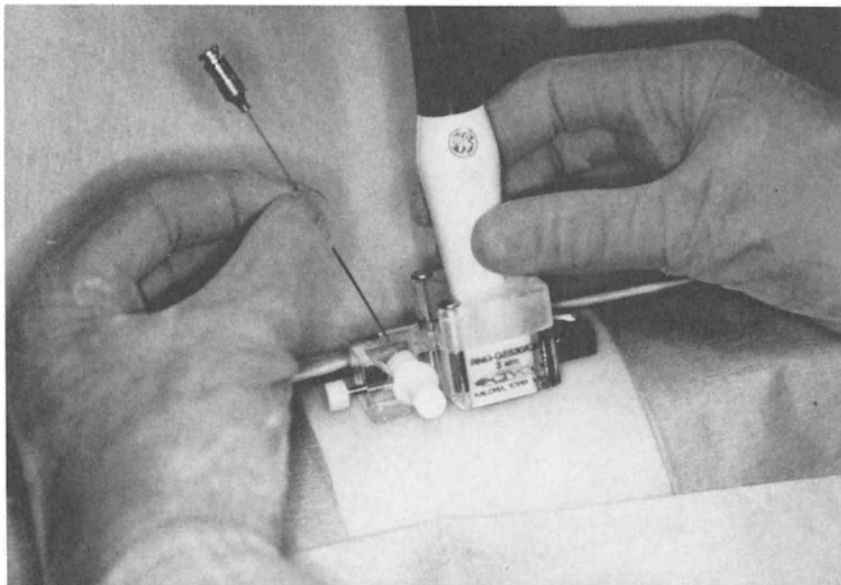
Percutaneous umbilical blood sampling: needle guide using sector ultrasound.
